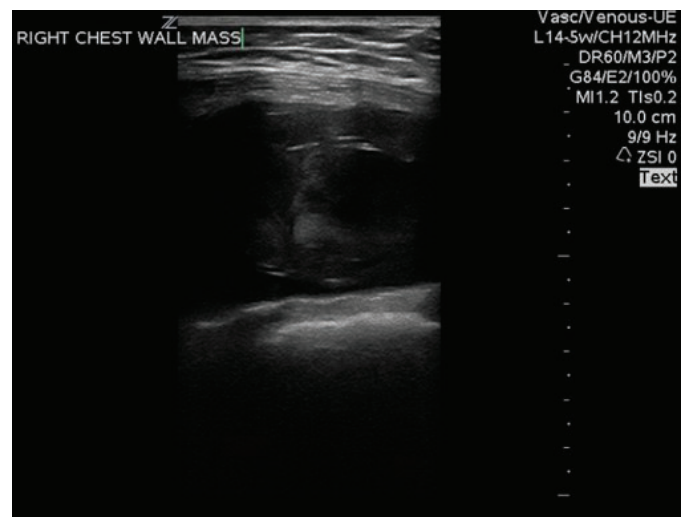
B-mode ultrasound image of the chest wall mass obtained with a linear transducer.
